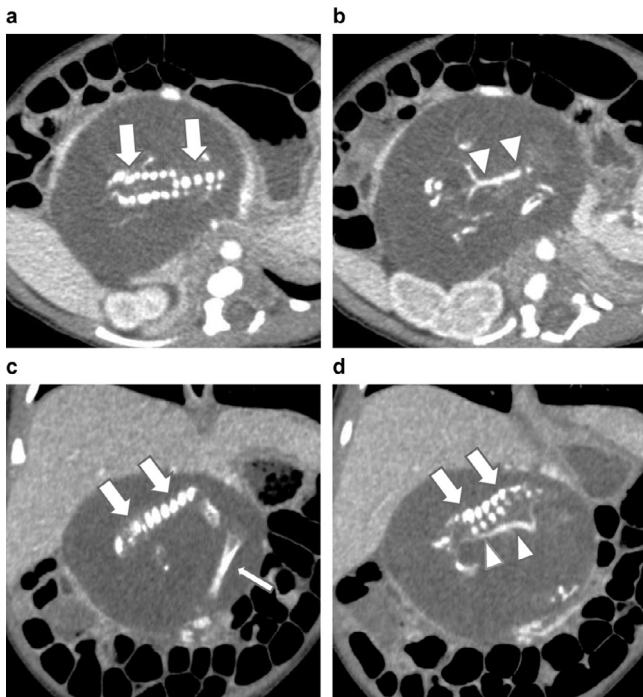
Abdominal contrast-enhanced CT on the day of visit (a, b) Axial and (c, d) coronal multiplane reformats of enhanced-contrast CT of the abdomen revealed a retroperitoneal cystic mass of approximately 6 cm. A spine-like bone structure (thick arrow), limb-like bone structure (thin arrow), and a blood vessel-like elongated structure (arrowhead) were observed within the cystic mass.
